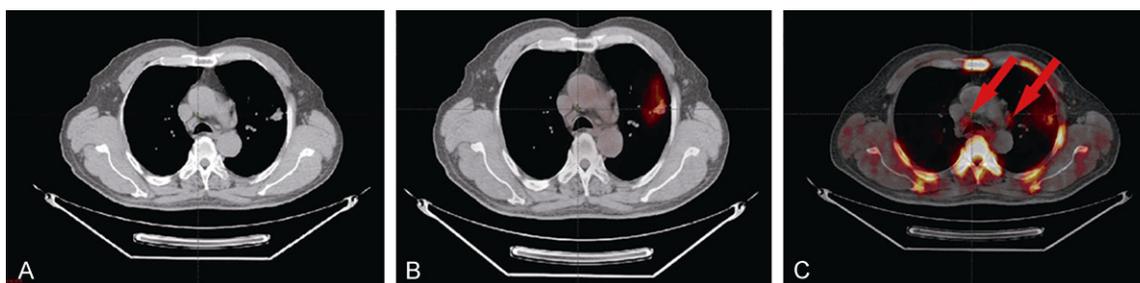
¹⁸F-FDG PET/CT showed no uptake in the mediastinal region, whereas ¹⁸F-FLT PET/CT showed the mediastinal lymph node metastasis. Pathologic examination proved the metastasis. A-C showed CT, ¹⁸F-FDG and ¹⁸F-FLT PET/CT imaging of patient 13, respectively.
